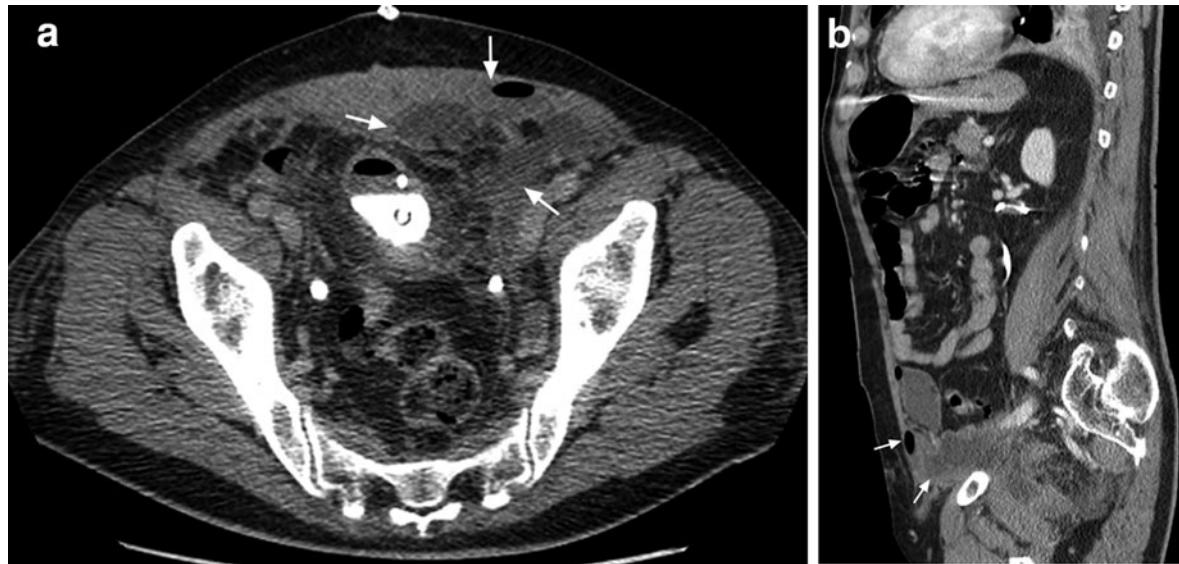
Abscess within the abdominal wall after prostatic surgery in a 74-year-old man. a, b Axial and sagittal contrast-enhanced reformatted CT scans of the lower abdomen show large fluid collections into the Retzius space spreading through the fascia transversalis into the abdominal wall containing gas
